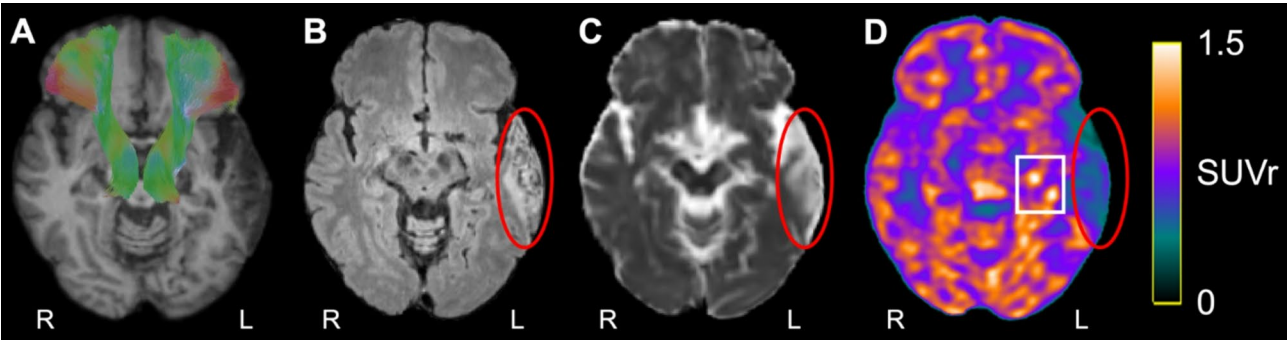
Brain PET/3T-MR images from a 78-year-old male stroke patient (patient #1) at 6-months post-stroke: (A) white matter tractography using TractSeg shows right and left anterior thalamic radiation bundles (coloured lines) overlaid onto T1-weighted MRI; (B) T2-weighted FLAIR shows index infarct (red circle); (C) apparent diffusion coefficient (ADC) map shows elevated ADC within index infarct (red circle); and (D) [¹⁸F]FEPPA-SUVr map shows elevated [¹⁸F]FEPPA uptake (white rectangle) ipsilateral to index infarct (red circle) and decreased [¹⁸F]FEPPA uptake within index infarct compared to contralateral hemisphere
